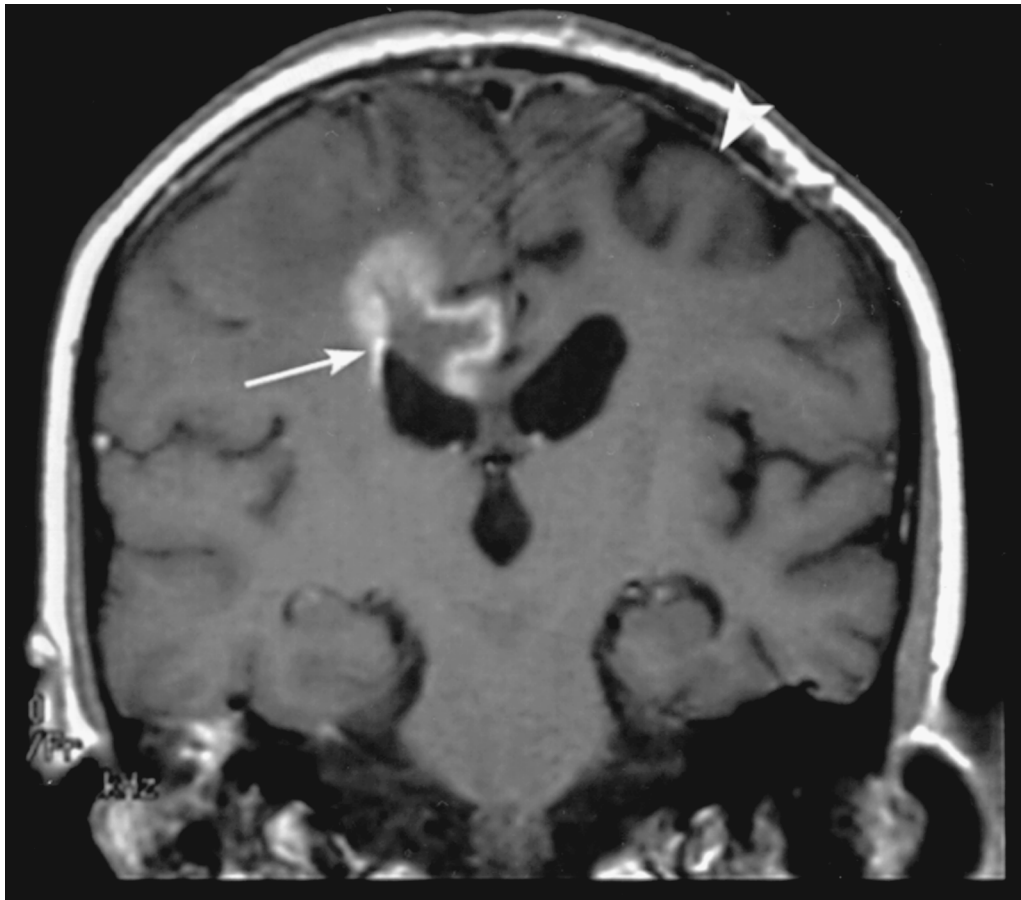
Post-contrast coronal T₁-weighted MRI of the brain. Biopsy-proven radiation necrosis affected the contralateral hemisphere (arrow) and involved the corpus callosum (C). The patient was status post-resection of glioblastoma in the left frontal lobe (arrowhead points to craniotomy site) followed by radiation and chemotherapy.
